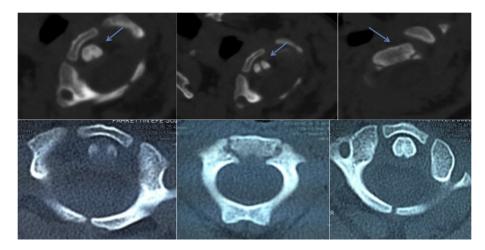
The CT images (upper) showed a rotatory subluxation of 30° in atlanto-axial joint of C2 vertebra. It is observed that the rotation improved in following images.
